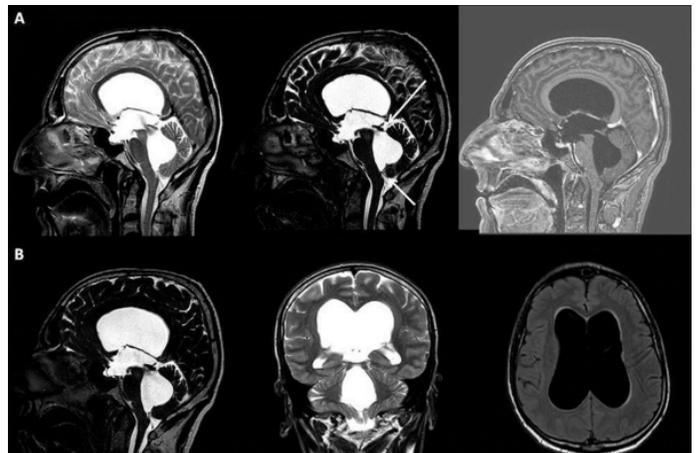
65 years old and male, the arachnoid cyst is seen in the fourth ventricle and disrupt the circulation of CSF is seen in MRI images A) T2 sagittal, T1 sagittal and coronal with contrast images B) Periventricular edema is seen in T2 axial image C) V-P shunt was seen on CT images after the first operation
